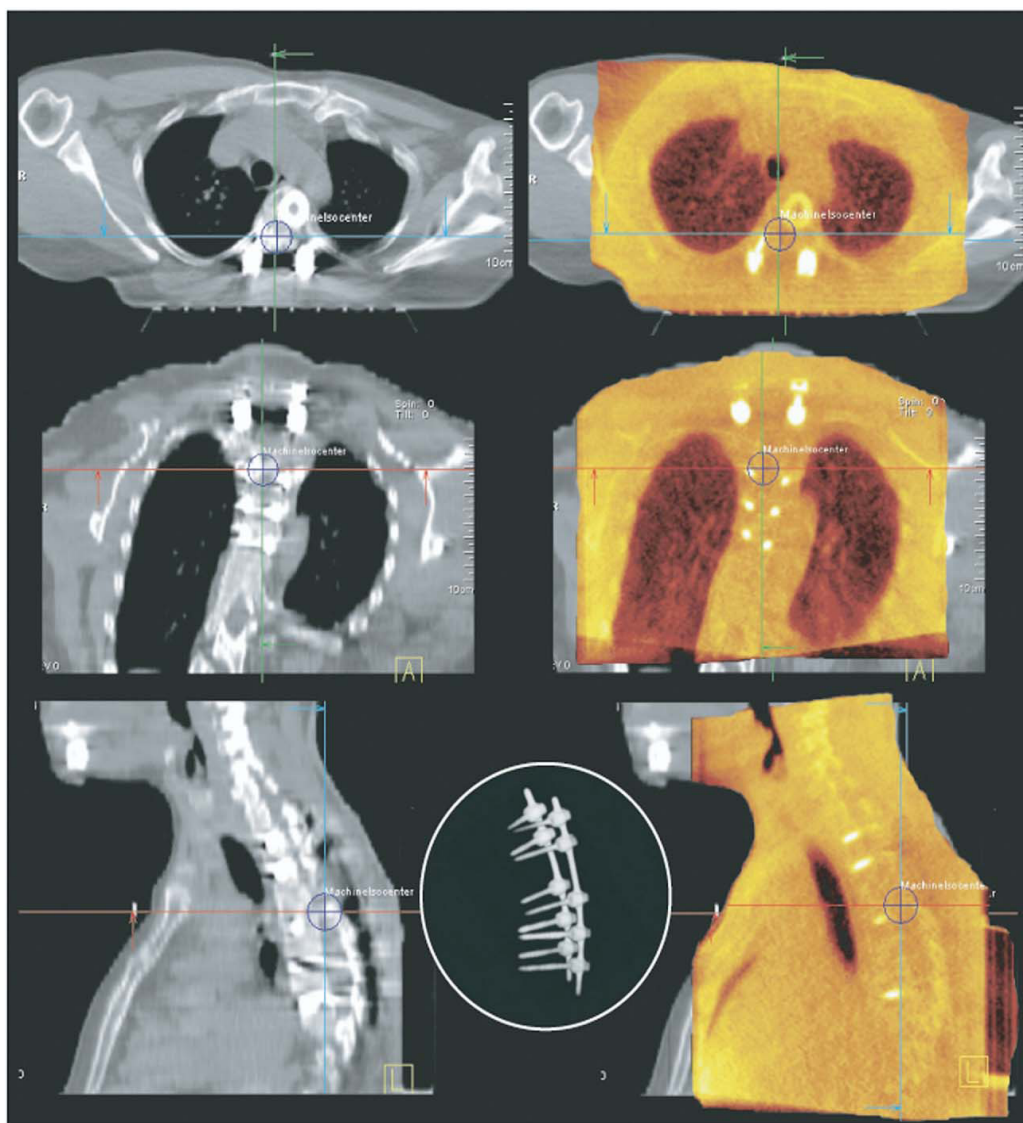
Three-dimensional (3D) image registration of megavoltage cone-beam computed tomography (MV-CBCT) (orange) with planning CT (grayscale) in all 3 planes. Inset demonstrates 3D MV-CBCT reconstruction of hardware without typical artifact.
